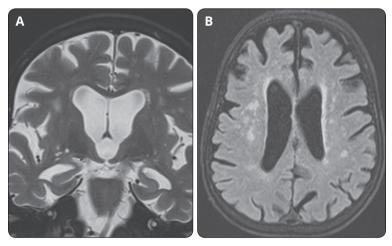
A. Coronal T2 image of sample with the MTA score 3. B. FLAIR image of sample with the SCWMH score 3 and PVWMH score 2
